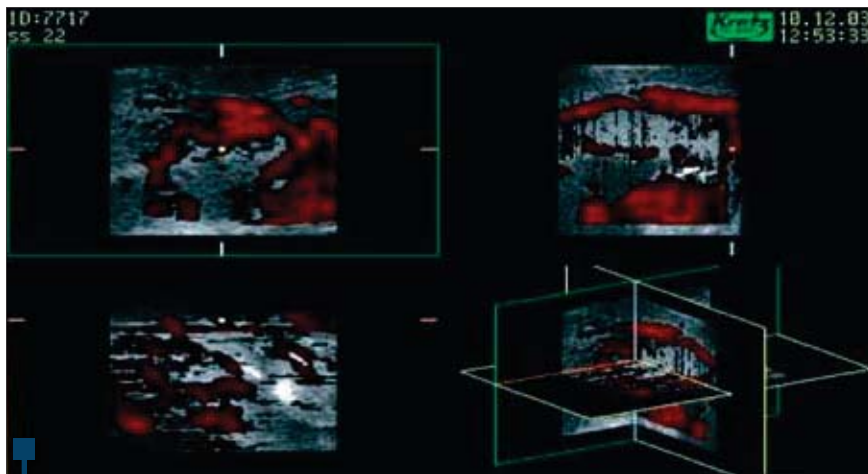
3D ultrasound - placenta represented in the “niche” mode
